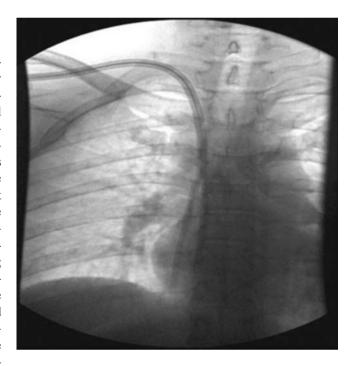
Chest X-ray showing a right internal jugular split-tip tunneled dialysis catheter
